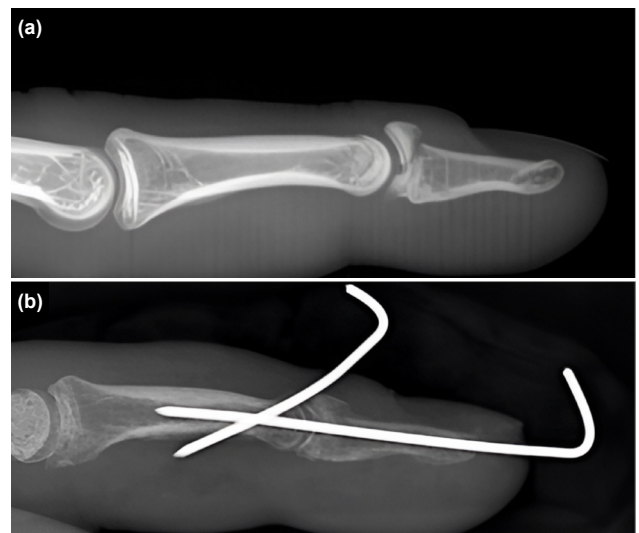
Preoperative lateral X-ray (a) and postoperative lateral X-ray (b).
